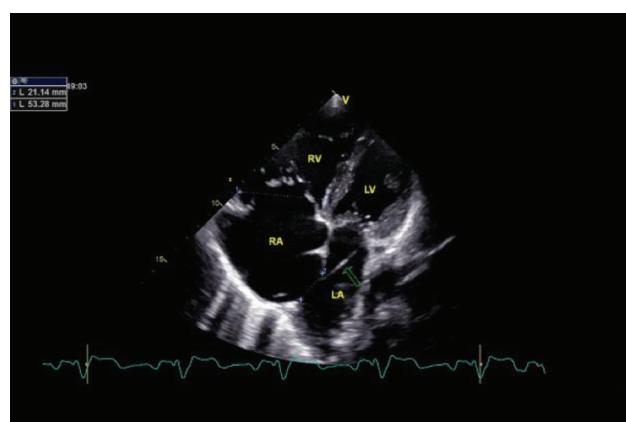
Transthoracic apical four chamber view of the atrial septal defect with a pacemaker electrode (arrow) passing through interatrial communication and stimulating the left ventricle.
